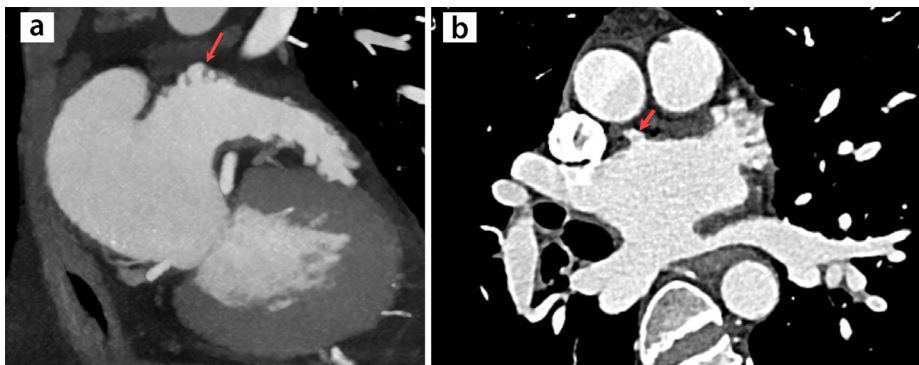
(a, b) Left atrial outpouchings in patients on coronary computed tomography (CT) angiography. (a) Multiplanar reformatted CT image depicting multiple outpouchings in the left atrium with trabeculated contours and narrow necks (arrow), consistent with accessory appendage. (b) Multiplanar reformatted CT image revealing an outpouching in the left atrium with smooth contours and a broad neck (arrow), consistent with diverticulum.
